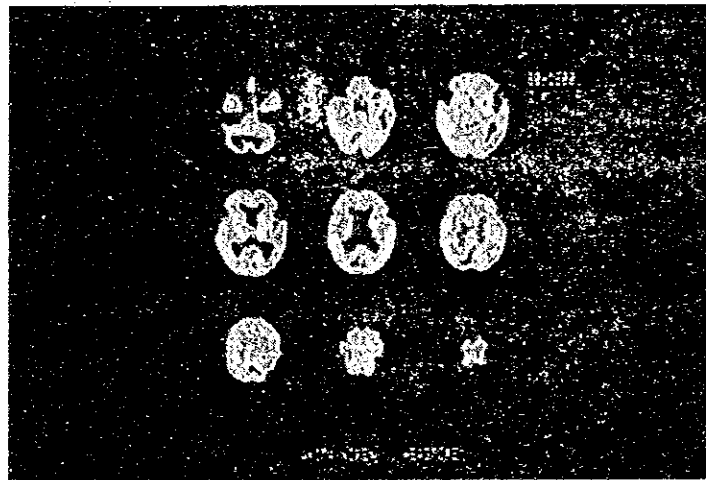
SPECT images using ^{99m}Tc -HM-PAO
